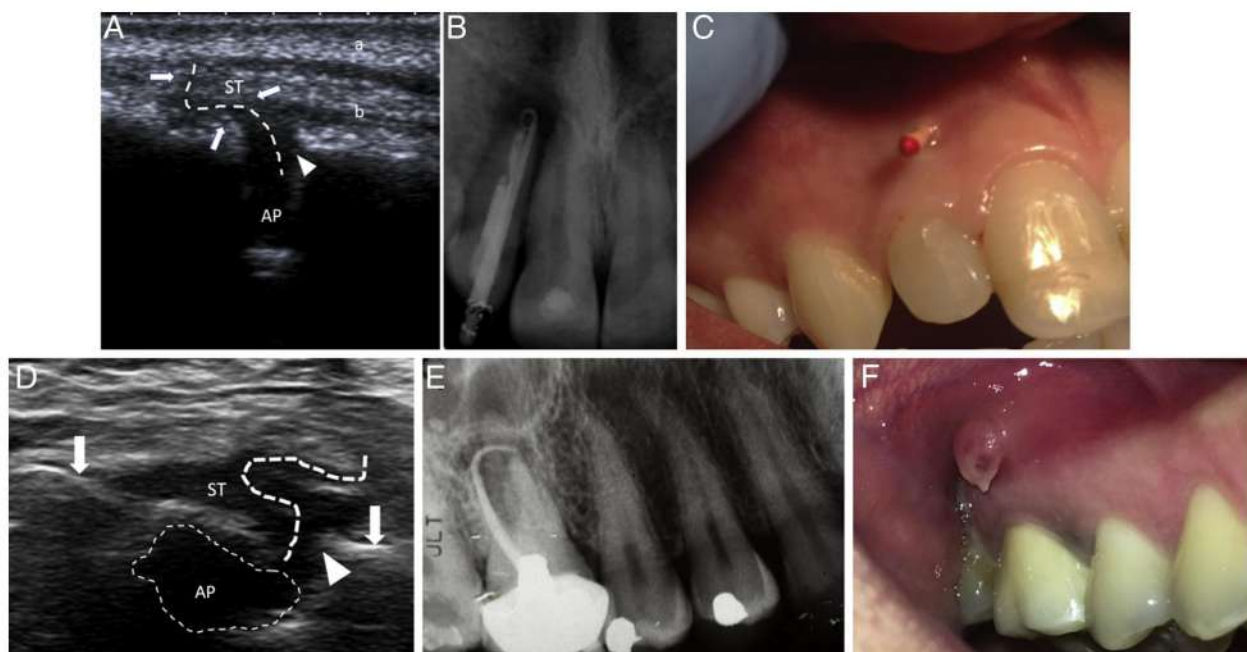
(A) An ecographic representation of an ST interrupting the cortical bone plate (*arrowhead*) depicted as a dishomogeneous, hypoechoic pathway (*interrupted line*) lined by echogenic and reinforced walls (*arrows*). (B) The same ST traced with a periapical radiograph (tooth #7). (C) The corresponding clinical image. (D) Ecographic tracing of another ST interrupting the cortical bone plate (*arrows*) through a breach (*arrowhead*). (E) The same ST traced with a periapical radiograph (tooth #3). (F) A clinical image of the corresponding hypertrophic stoma.
